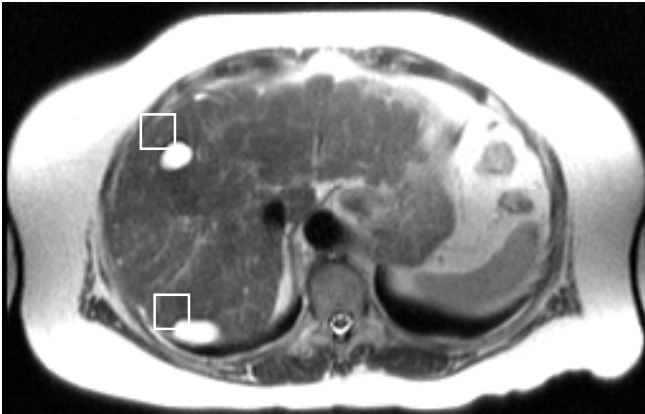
12 x 12 ROI block drawn on cyst in a MR image of the abdomen. cyst is a recently recognized genetic disorder characterized by the appearance of numerous cysts spread throughout the liver. A cyst may be identified as an abnormal fluid-filled sac-like structure.
